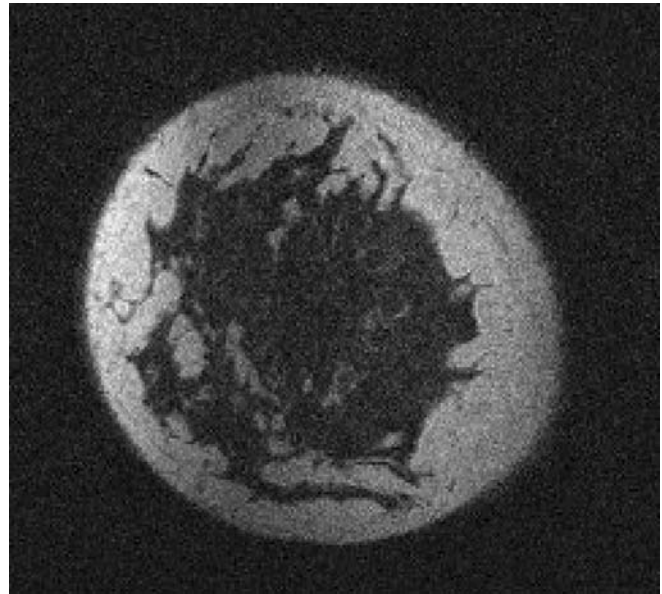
Non contrast breast MRI taken in the supine position with prototype breast coil array and motion compensation.
